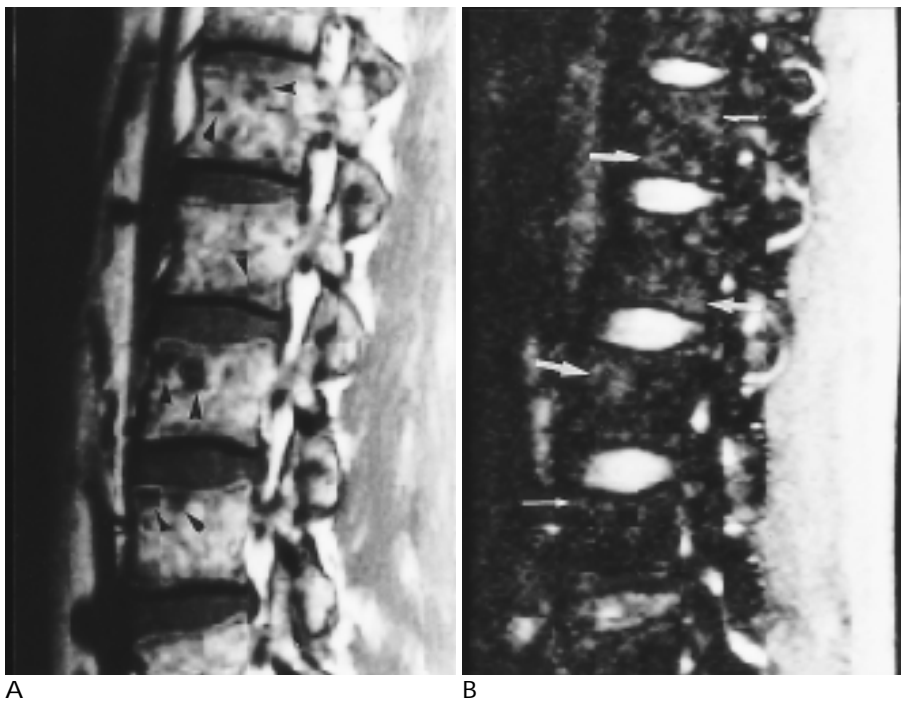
A 39-year-old man (patient No.16) with relapse after peripheral blood stem cell transplantation for acute myelocytic leukemia. Signal intensity of bone marrow is inhomogeneously high with small low signal nodules (arrow heads) on sagittal T1-weighted image(A, 560/30) and reversed low with high signal nodules(arrows) on STIR image(B, 1,200/30/120).
